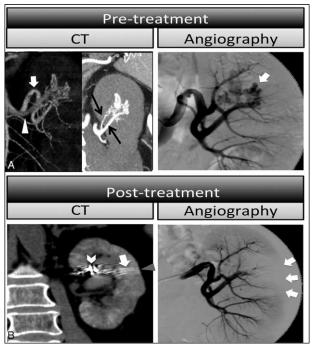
(A) Pretreatment image (CT image) CT angiography (CTA) with volume-rendering reformatted image of the left kidney (a) demonstrated a cirsoid-type renal arteriovenous malformation (AVM) at the upper pole of the left kidney with arterial feeder (bold arrow) and draining vein (triangular arrowhead). Oblique coronal image with maximal-intensity projection showed two arterial feeders (thin arrows, proximal and distal) arising from posterior segmental artery of the left kidney supply the renal AVM (angiography image). Transcatheter angiography of the left kidney confirms the CTA findings of renal AVM (bold arrow). (b) Posttreatment image (left) noncontrast-enhanced CT performed on the 5th postembolization day shows fine linear hyperdense striations in the left renal parenchyma (bold arrow). Note the confinement of the hyperdense striations within the renal contour (red triangular arrowhead) and also the height difference between the peripelvic embolizer (small arrowhead) and the striations (bold arrow) exclude beam-hardening artifact. (Right) Control angiography after the embolization showed complete obliteration of the renal AVM with resultant infarction at the lateral aspect of the mid portion of the kidney (bold arrows). CT, computed tomography.
